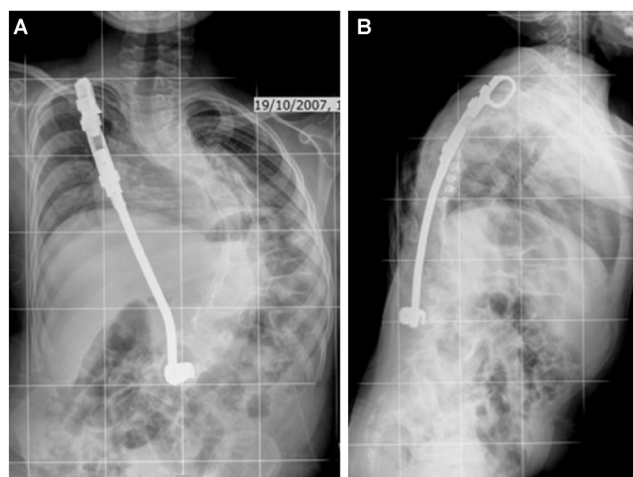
Antero-posterior (A) and lateral (B) view radiographs of the patient following insertion of VEPTR demonstrating the coronal deformity of congenital early-onset scoliosis and a rib to spine VEPTR on the right side. VEPTR, vertical expandable prosthetic titanium rib.
